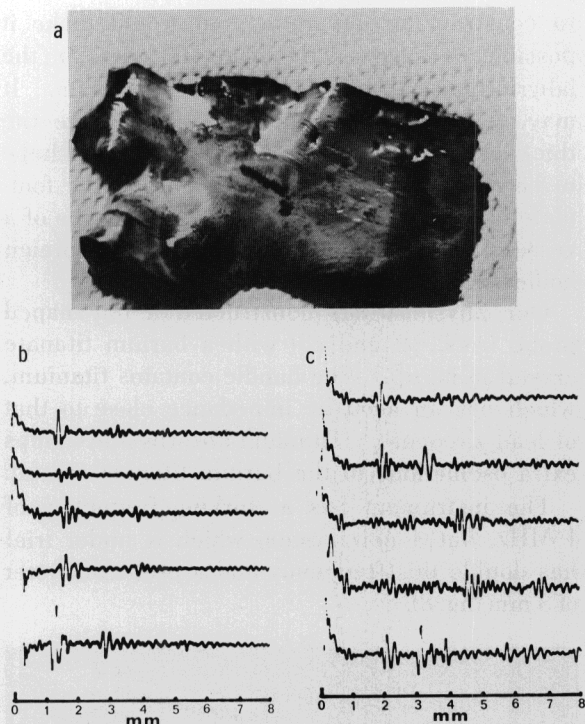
A: Piece of aorta from 28-year-old female. B: Sonograms of pieces of aorta of A. C: Sonograms from arteriosclerotic aorta of 70-year-old man.
